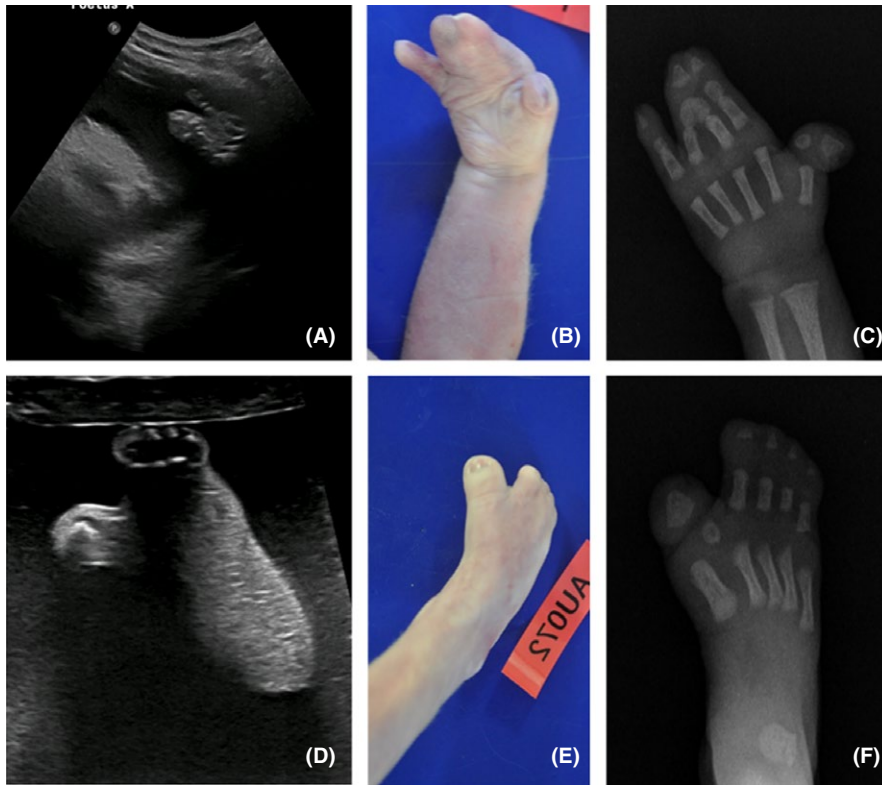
Abnormalities of the limbs. Prenatal 2D US (A and D), postmortem examination, (B and E) and radiography (C and F). D, E, and F. Enlarged and varus big toe of fetal foot. A, B, and C. Mitten hand with membranous syndactyly of fingers 2-3 and bony syndactyly of fingers 3-4
